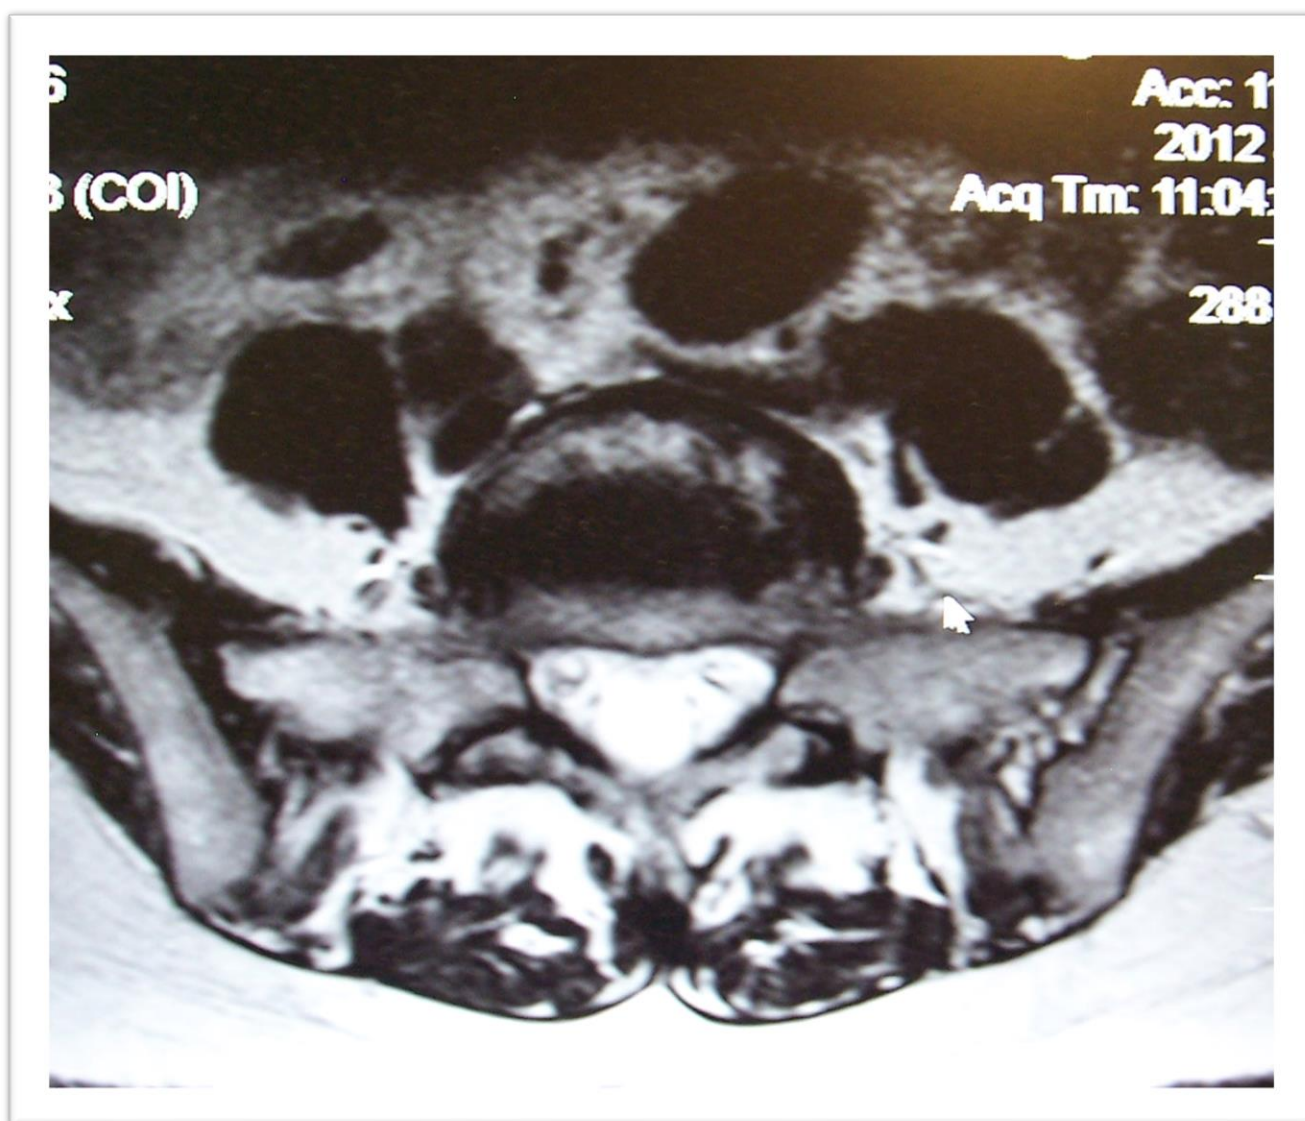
T1 weighted MRI transverse image demonstrating compression at L5/S1 level with broad bulging of the disc which is asymmetric with more on the left. The white arrow is an artifact.
